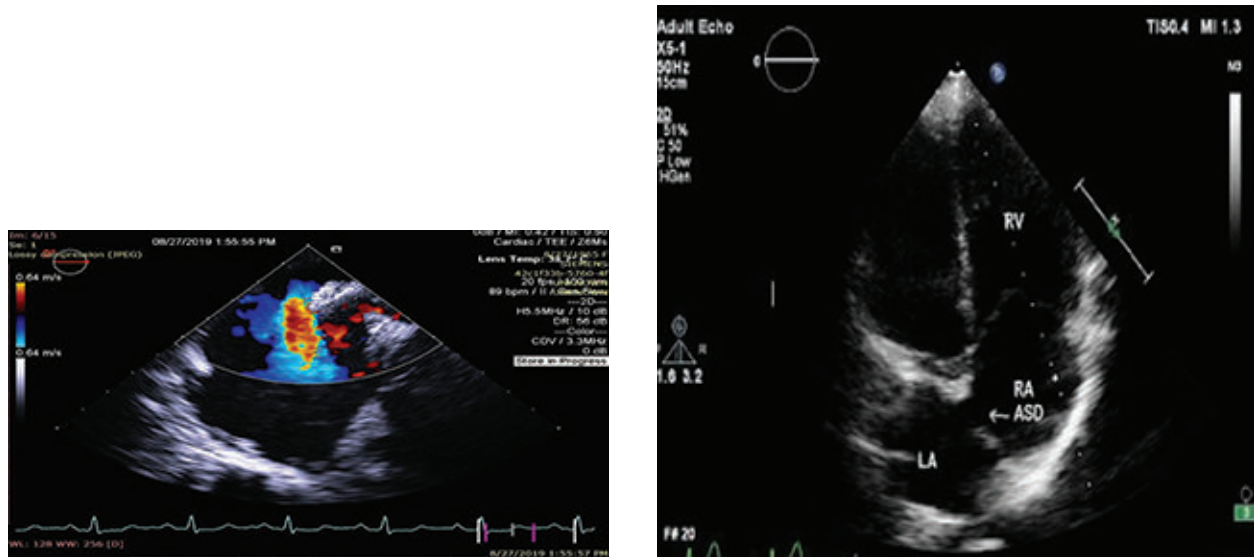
(a) Transoesophageal echocardiogram with colour doppler showing presence of left to right shunting across the atrial septal defect. (b) Echo view of residual atrial septal defect
